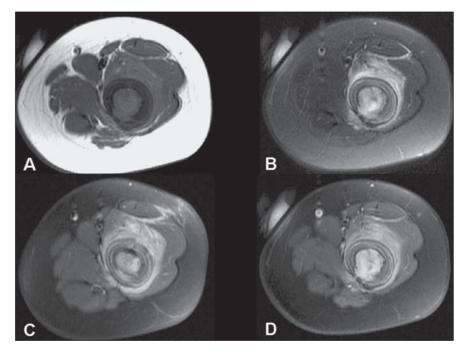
Magnetic resonance imaging — axial, T1-weighted image (A), T2-weighted image with fat saturation (B) and T1-weighted with fat saturation acquired after paramagnetic contrast agent injection (C,D).
